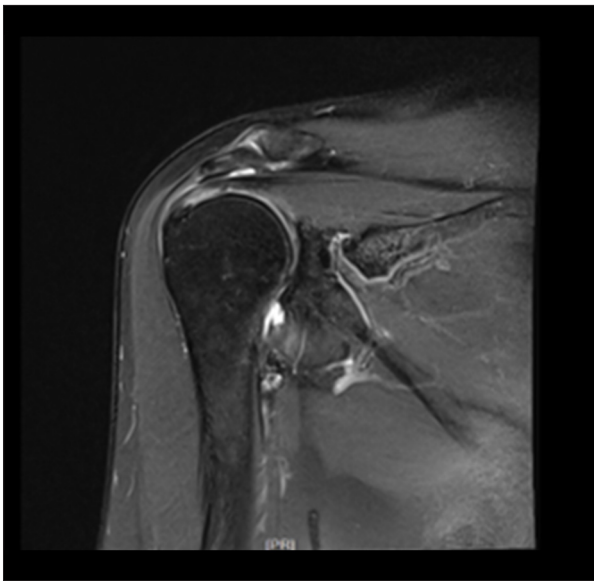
Preoperative imaging of rotator cuff injury. Preoperative coronal oblique T2-weighted fat-suppressed magnetic resonance imaging of the right shoulder from a representative patient. The image demonstrates a full-thickness tear of the supraspinatus tendon. This pattern of injury was representative of the majority of study participants who underwent arthroscopic rotator cuff repair.
